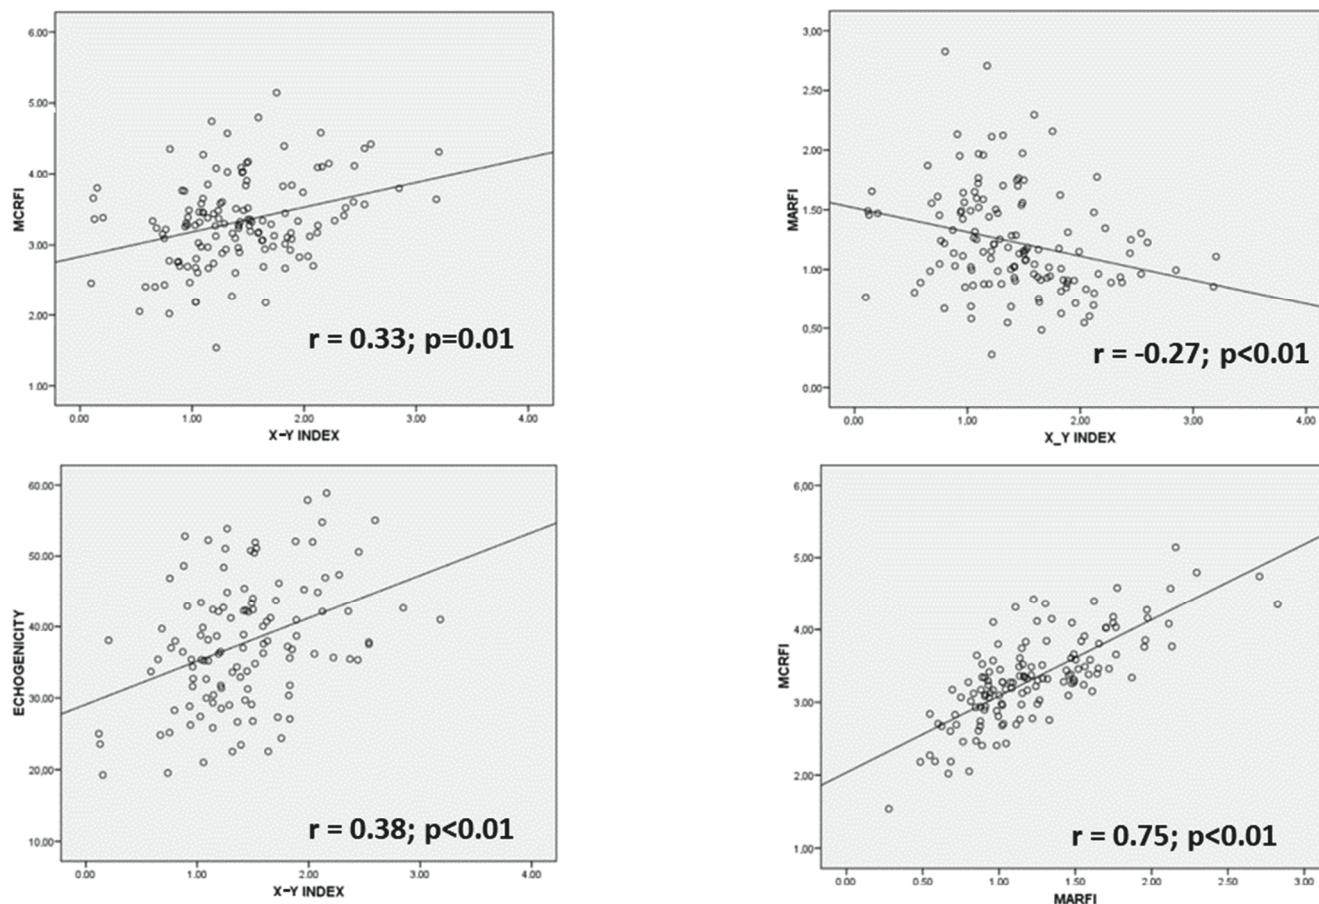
Regression graphics comparing ultrasonography variables. MARFI: muscle area of rectus femoris index; MCRFI: muscle circumference of rectus femoris index; X: transversal axis; Y: anteroposterior axis.
